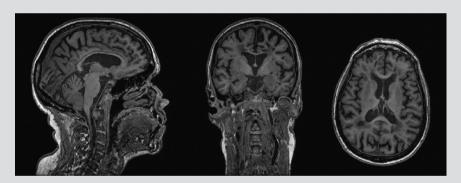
Example of a T1-weighted MRI sequence of an individual with MS, showing cortical atrophy.
